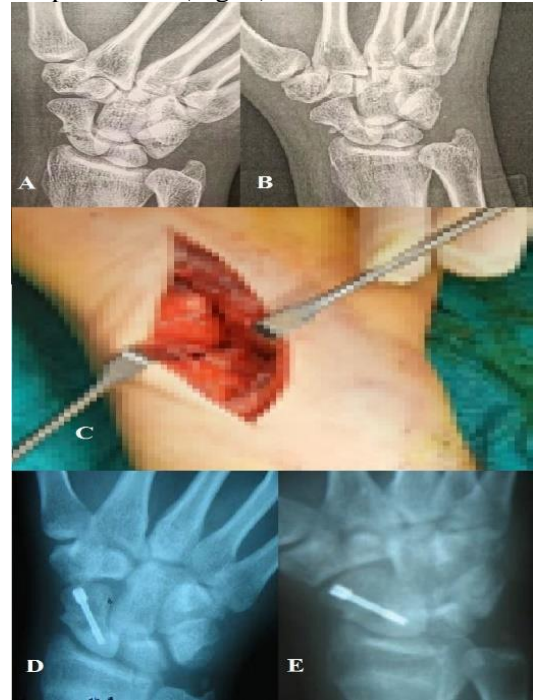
Preoperative and postoperative X-rays in open reduction and internal fixation by volar approach to scaphoid; A: preoperative X-ray in AP view, B: scaphoid view, C: the volar approach to scaphoid, D: postoperative X-ray in AP view, E: scaphoid view.
